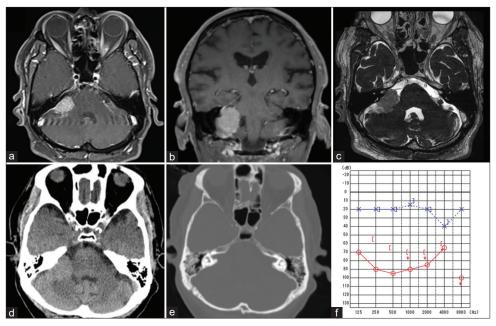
Preoperative brain magnetic resonance imaging showing a right-sided cerebellopontine angle (CPA) meningioma with associated effacement of the ipsilateral CPA cistern and cerebellar compression on gadolinium-enhanced T1-weighted image (a and b) and constructive interference in steady state (c). Brain computed tomography scan showing no calcification in the tumor and normalsized and symmetrical internal acoustic meatus (d and e). Preoperative pure-tone audiometry showing 90 decibels in the right ear (f).
